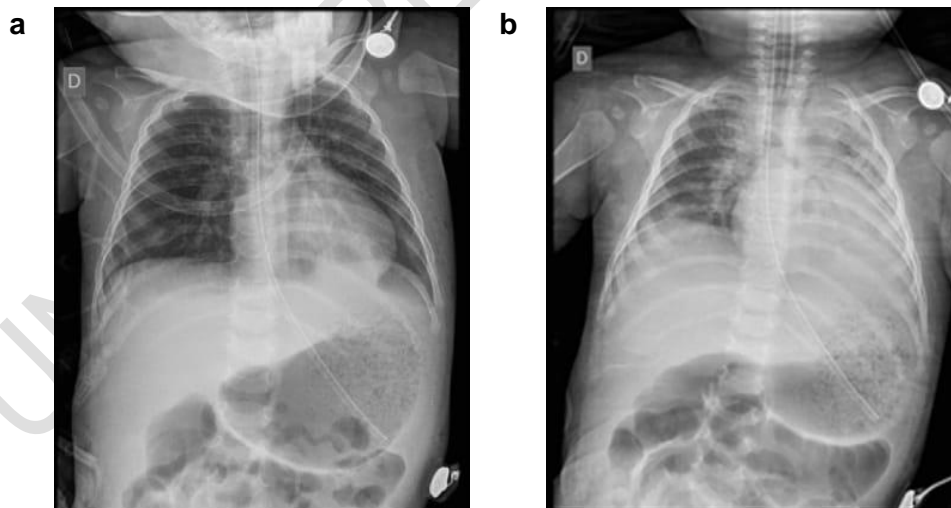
Plain anteroposterior chest radiographs. X-ray on admission, observing right parahilar infiltrates with air bronchogram (a). Chest X-ray 48 hours after admission, with consolidation in the entire left hemithorax, loss of the contour of the cardiac silhouette and the ipsilateral costo-diaphragmatic angle (b).
